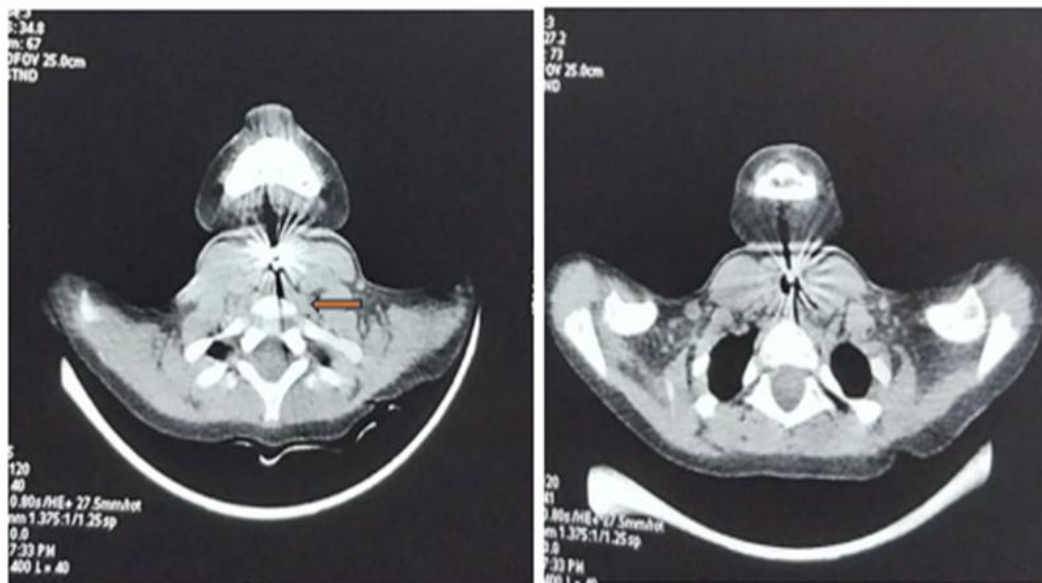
Neck CT scan axial section: The laryngeal airway foreign body (arrow).
